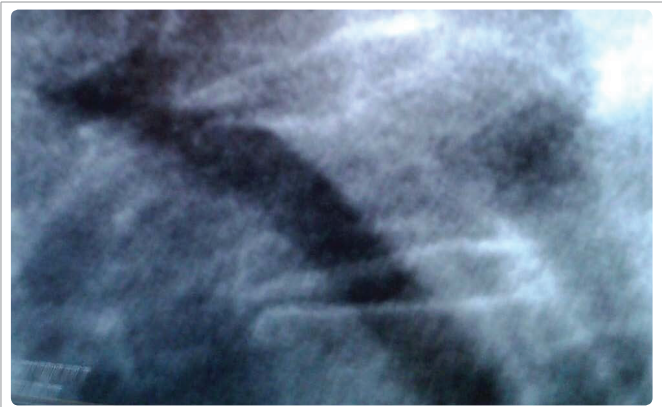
Chest x-ray: note undiagnosed T4 area mid-upper cortex depression.
